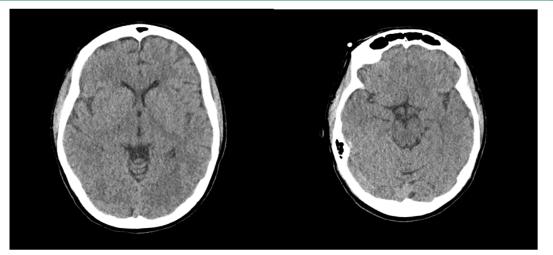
Noncontrast CT and CT venogram of the head.
